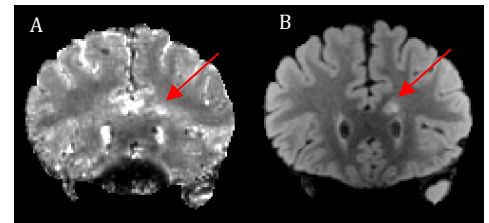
Lesion showed in T2* map (A) and FLAIR image (B)
